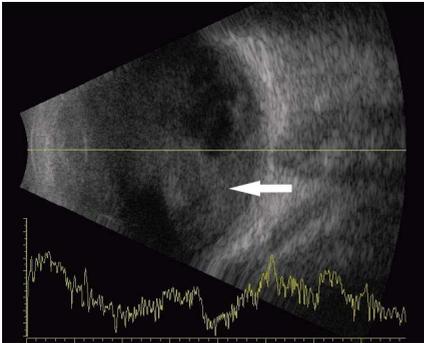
B scan ultrasonography at day 1 postoperatively showing dense vitreous opacity.
